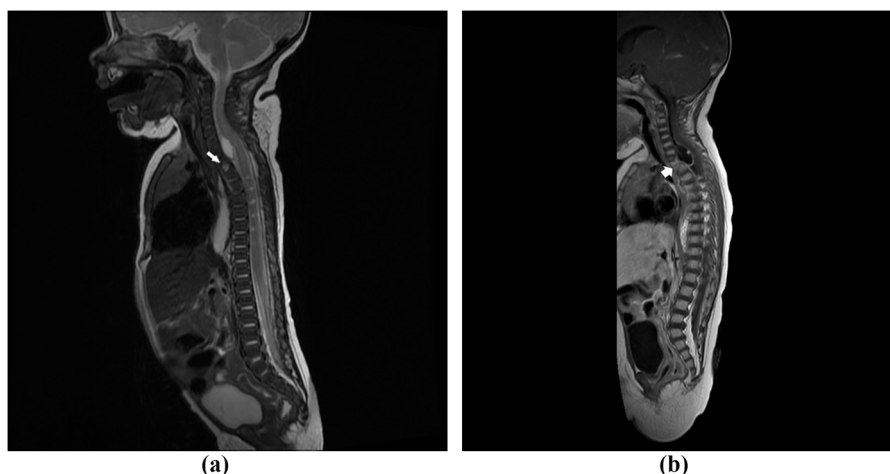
2a: Mid-sagittal T2W MRI prior to surgery, notice the trans vertebral communication channel (white arrow). 2b: Mid-sagittal T1W MRI with gadolinium performed between the two surgeries. Notice the ventral location of the cyst in the intradural compartment. There is no clear plane between the cyst and the spinal cord. The vertebral body defect anterior to the cyst is indicated by a wide arrow.
